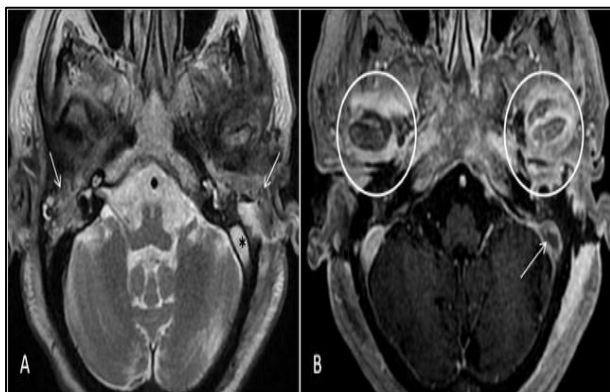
(A) Axial T2-weighted image shows signal changes compatible with effusion/inflammation in the bilateral tympanic cavity (arrows) and signal void loss in the left sigmoid sinus (asterisk); (B) on contrast-enhanced axial T1-weighted image, contrast enhancement in and around the temporomandibular joint space on both sides (circles) and filling defect compatible with thrombosis in the left sigmoid sinus (arrow) are visible.
